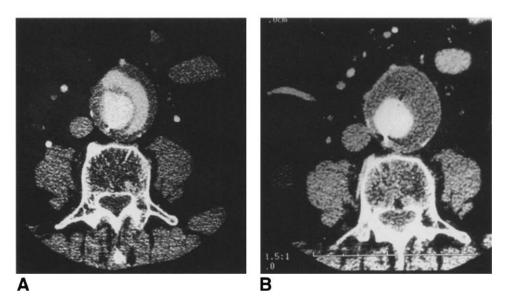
A, Discharge CT scan shows endoleak with crescent-shaped accumulation of contrast material outside confines of endograft lumen but within sac of abdominal aortic aneurysm. B, Follow-up CT scan 6 weeks after discharge demonstrates spontaneous sealing of endoleak and no contrast enhancement of AAA sac.
